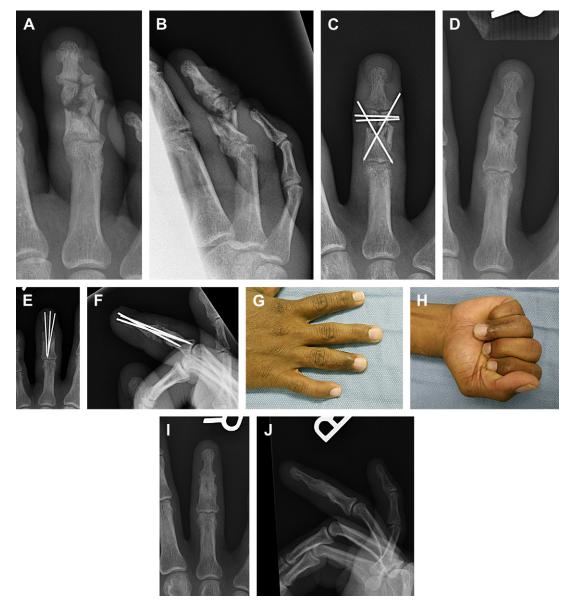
Clinical example of patient with comminuted open fracture of middle phalanx. Preoperative posterioranterior (*A*) and oblique (*B*) radiographs. Initial stabilization was with Kirschner (k)-wires (*C*). Persistent painful nonunion 8 months following injury (*D*) treated with correction of nonunion with bone graft and arthrodesis or arthritic distal interphalangeal (DIP) joint (*E*, *F*). Final clinical (*G*, *H*) and radiographic (*I*, *J*) appearance.
